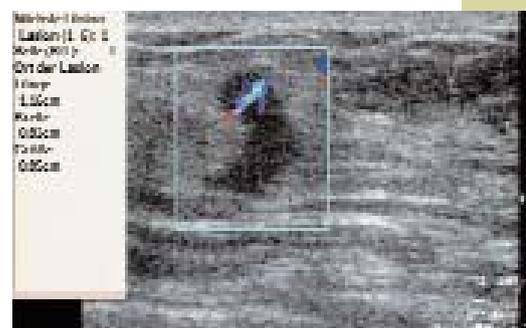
Finding from Fig. 16 in color Doppler: suspect vascularization with a radial pathway into the lesion
